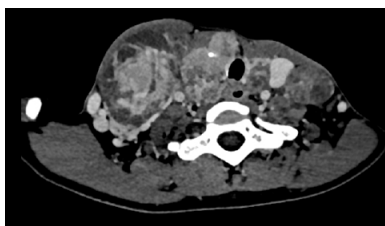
Post contrast axial and coronal reformation of CT Neck shows metastatic neck nodes of thyroid CA compressing right IJV
